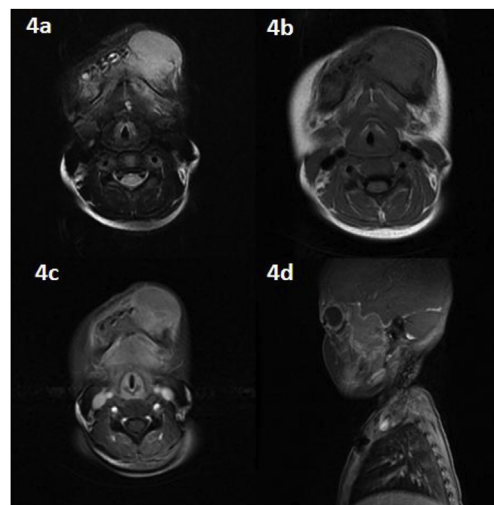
MRI images demonstrating the submandibular mass of the patients. 4a T2-weighted (T2-W) image revealed hyperintensity of the lesion. T1-W 4b axial and 4d sagittal images showed a huge facial mass mostly hypointense to the brain. 4c Contrast-enhanced T1-W image demonstrated heterogeneous contrast enhancement.
